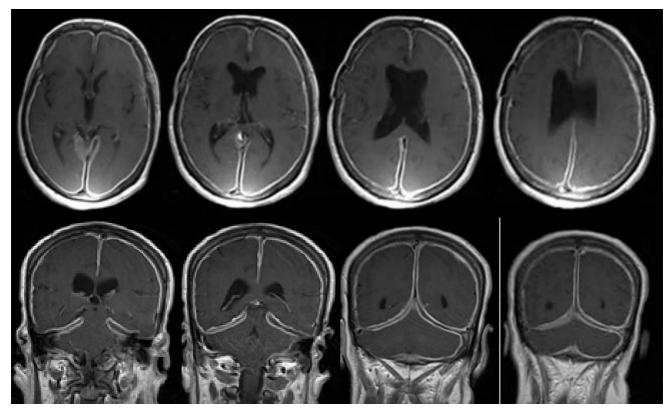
Brain MRI shows a decrease in thickening of pachymeninge in T1 WI with contrast DISCUSSION
